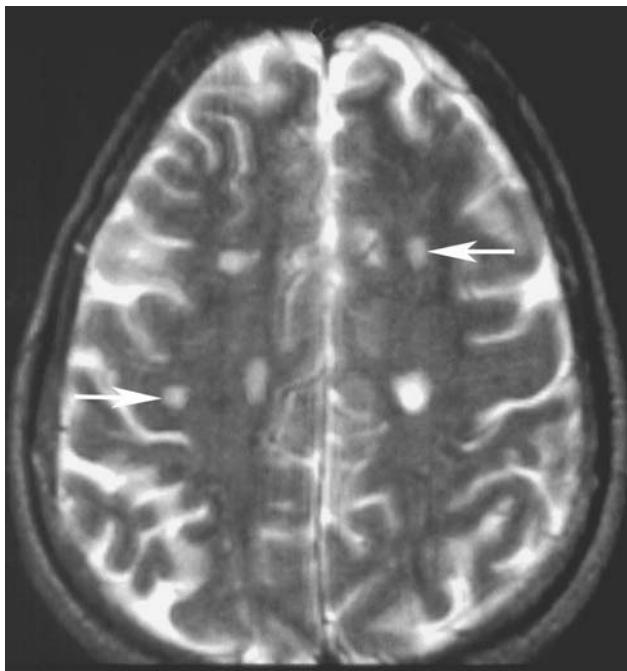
A T2-weighted MRI scan of a brain of a patient with multiple sclerosis. The plaques (arrows) appear white on MRI and have a predilection to form around the ventricular system. This horizontal plane of section is just dorsal to the lateral ventricles.
